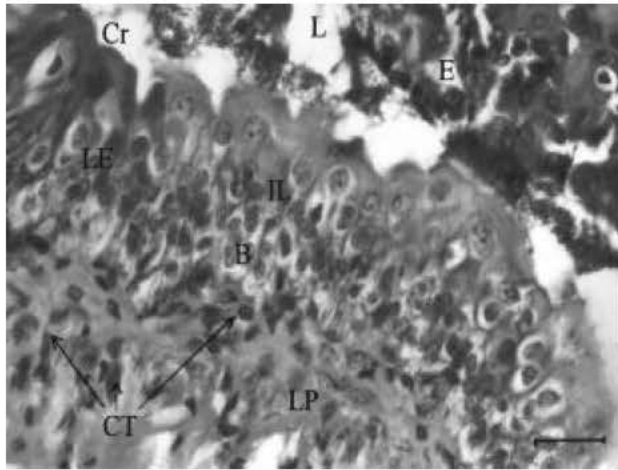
Many changes are seen in lamina epithelialis and lamina propria. LE: Lamina Epithelialis, LP: Lamina Propria, L: Lumen, B: Basal Cells, IL: Intermediate Layer Cells, Cr: Crusty, CT: Connective Tissue Cells, E: Epithelial Cell Losses. Masson, bar 10 μ m
